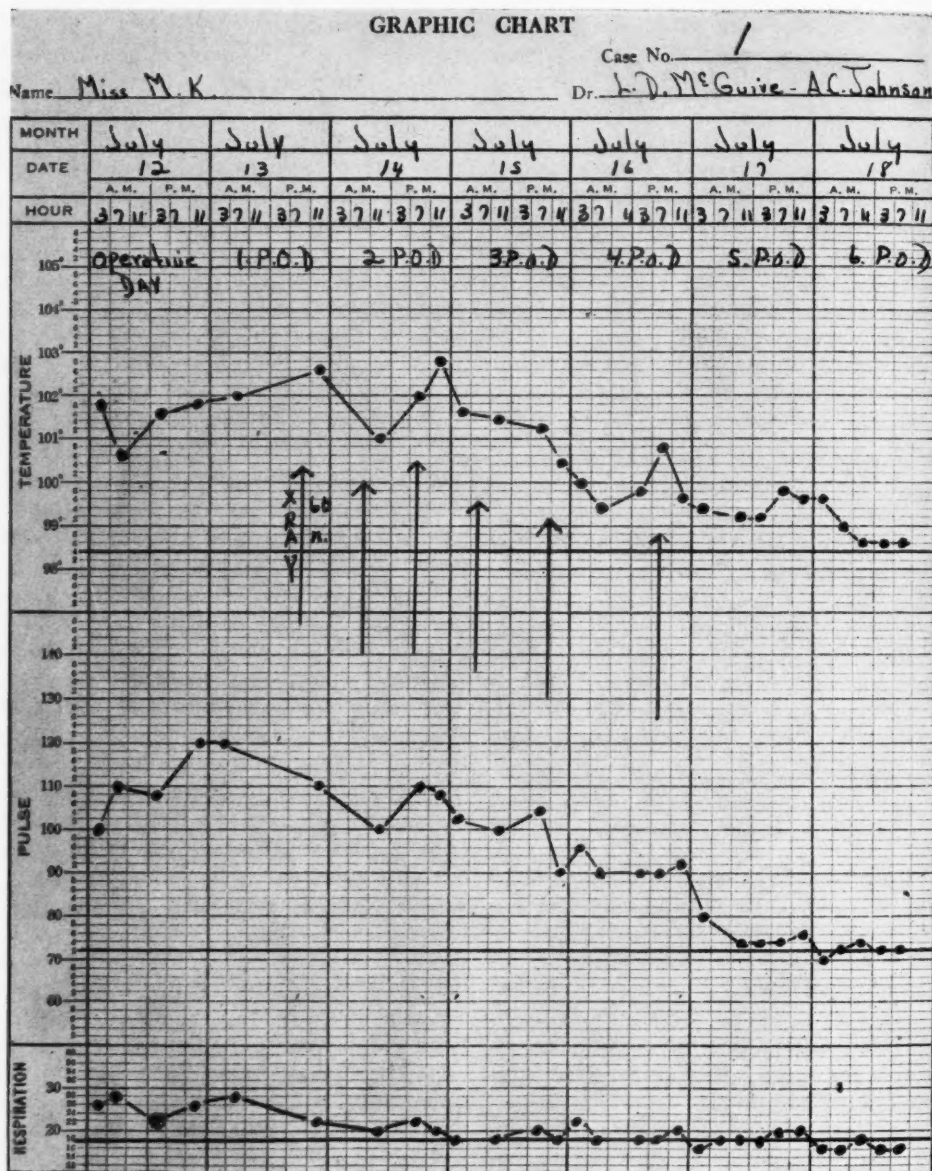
Case 1. Diagnosis: Peritonitis, post-operative gangrenous appendicitis. X-ray technic: kv. 110; ma. 5; distance 50 cm.; filter 2 mm. Al; r units, 60 per treatment, 360 total; port, abdomen anteriorly; result, excellent.
